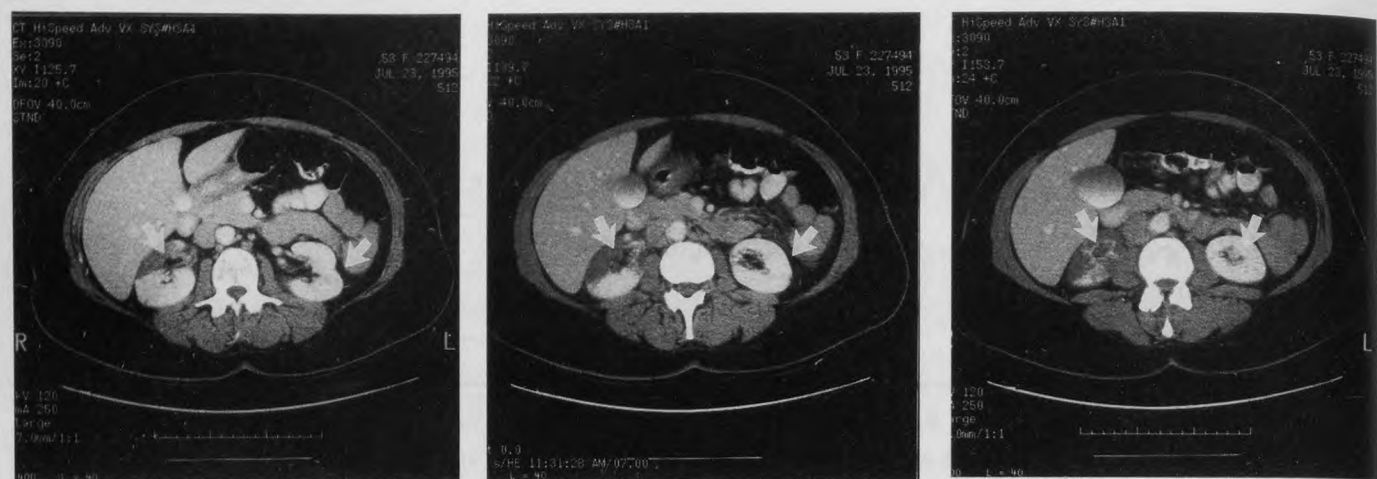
Contrast-enhanced computed tomographic scans, moving from the midlevel (*above, left*) to the lower pole (*above, right*) of the kidneys. The enlarging area of decreased attenuation in the right kidney (left arrows) indicates an infarction. Compare with the normally enhancing left kidney (right arrows).
